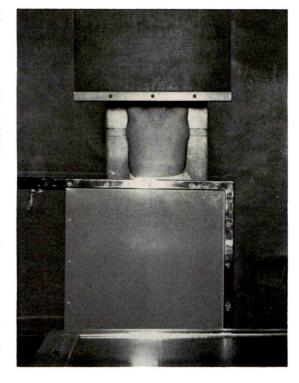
Appearance of the infant for a posteroanterior chest roentgenogram as seen from the position of the roentgenographic tube. The shielding has confined all exposure to the area of the chest.
